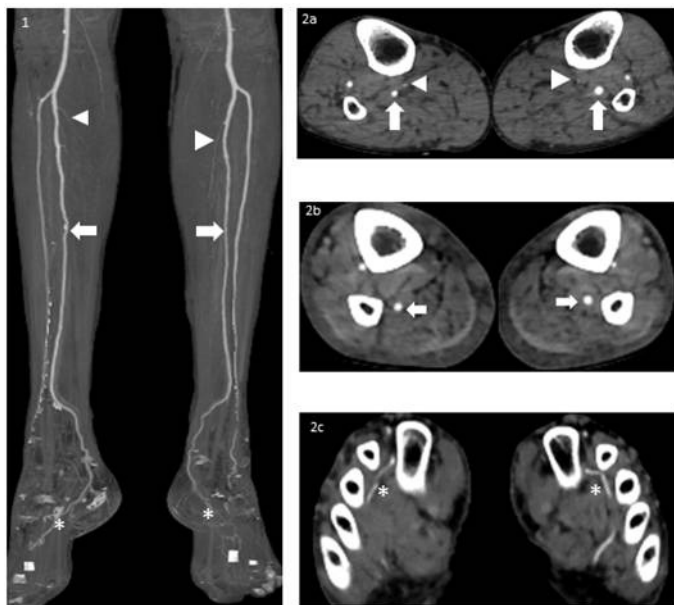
Preplanning free fibular flap surgery MIP coronals (1) & axial CTA images from the knees below at corresponding levels (2a,2b,2c) in a case oral cancer being evaluated for mandibular reconstruction demonstrating hypoplastic posterior tibial artery (arrowheads), enlarged peroneal artery (arrows) continuing as the lateral plantar artery
